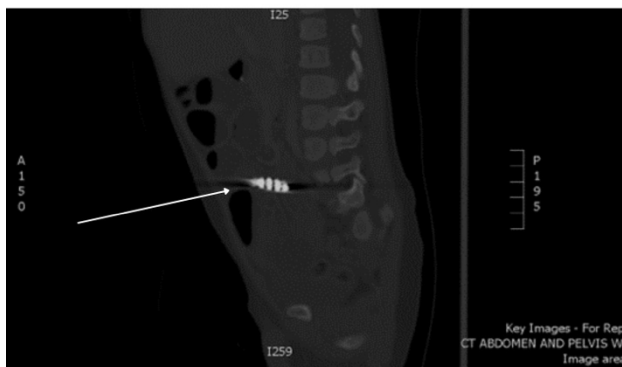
CT Abdomen and Pelvis with Contrast (Axial View)
